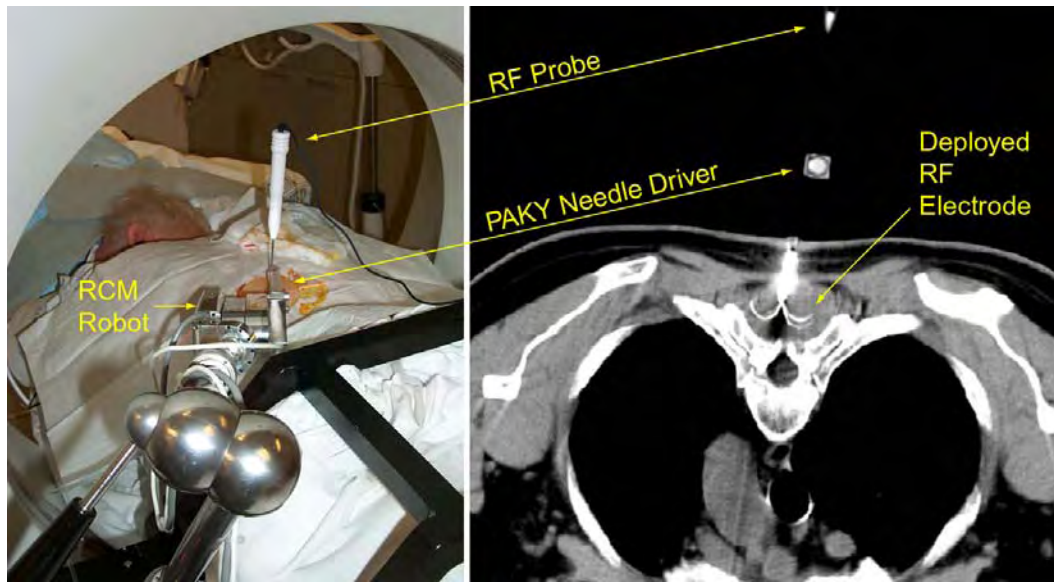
CT-guided RF ablation with PAKY-RCM system and laser based registration
